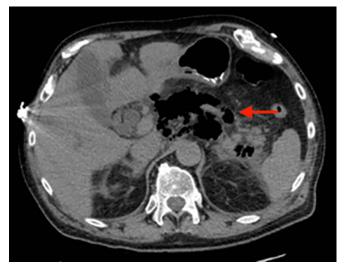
Abdominal computed tomography showing significant pancreatic and peripancreatic gas-containing fluid collection, initially concerning for perforated viscus.
